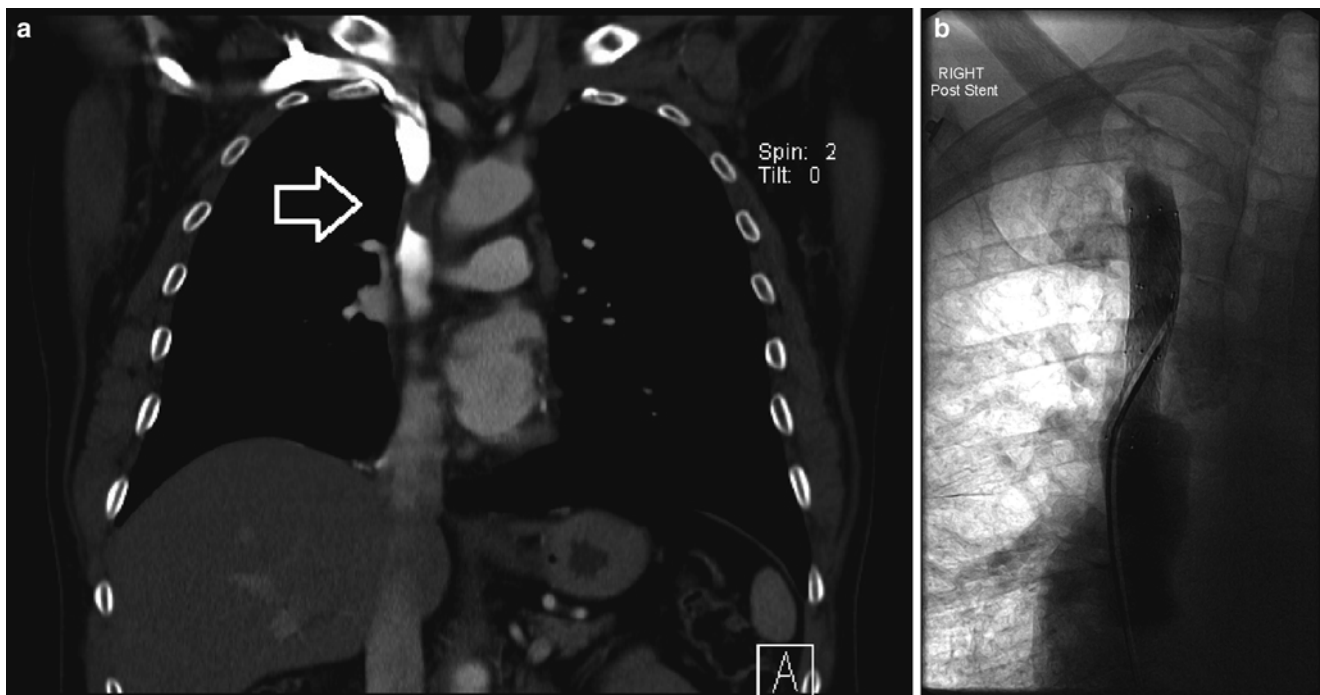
(a) CT coronal view superior vena cava syndrome. *White open arrow* indicates area of narrowing on contrasted study. (b) Deployment of a stent across the superior vena cava
